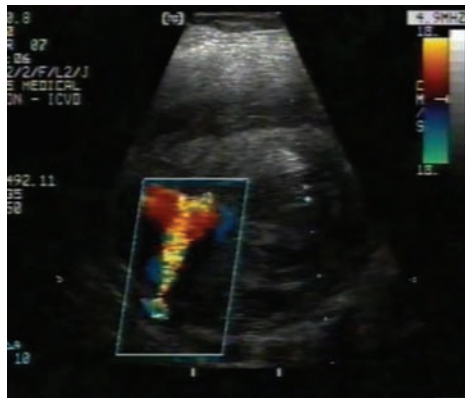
Doppler study showing continuous flow into the psuedoaneurysm through a narrow neck
